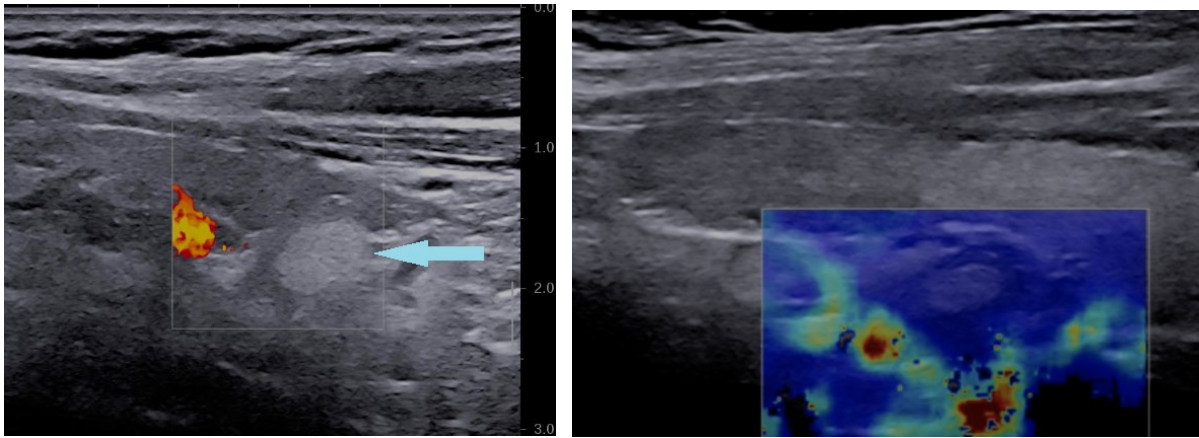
Right inferior normal parathyroid gland: hyperechoic, oval, homogeneous on ultrasound (left); soft on elastography, completely blue color-map (right)
